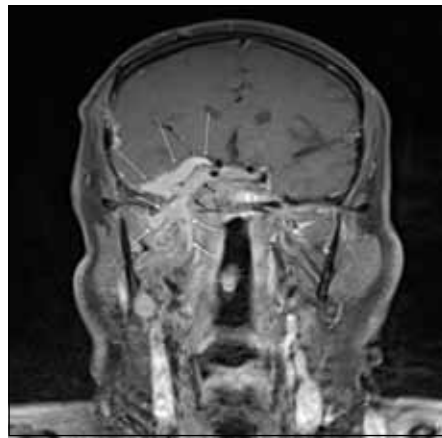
Coronal T1 gadolinium-enhanced magnetic resonance imaging demonstrates an extra-axial, avidly enhancing lesion along the base of the right temporal fossa (long white arrows) which extends into the right cavernous sinus (black arrows), and right infratemporal fossa and masticator space (short white arrows). The features are in keeping with a skull base meningioma with extracranial extension.
